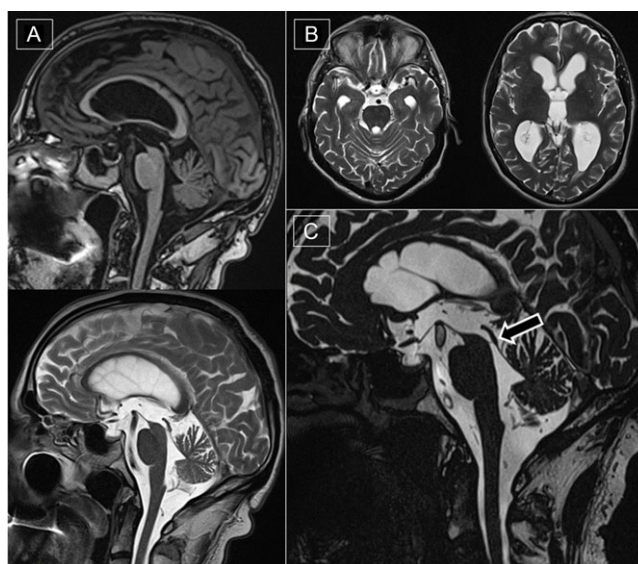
(A) midsagittal T1- and T2-weighted images demonstrating enlargement of the lateral and third ventricles with upward bowing of the corpus callosum and a “hummingbird sign” in the rostral brainstem. (B) Axial T2-weighted images confirm ventriculomegaly with minimal periventricular high signal. The fourth ventricle is normal in calibre. (C) Midsagittal constructive interference in steady state (CISS) sequence confirms the presence of an aqueductal web (arrow) with funneling of the aqueduct.
